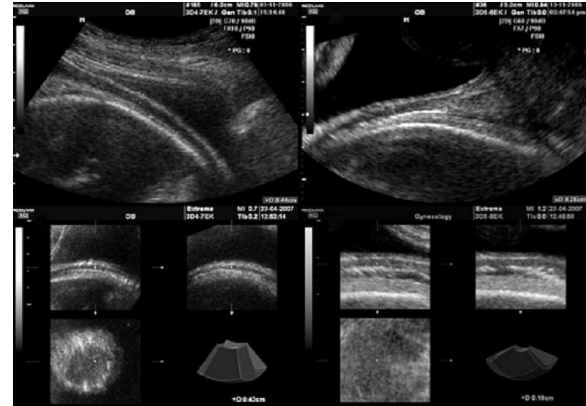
Images demonstrating measurement of the entire thickness of the lower uterine segment (LUS) by transabdominal two-dimensional (a) and three-dimensional (c) ultrasound, and of the muscular layer of the LUS by transvaginal two-dimensional (b) and three-dimensional (d) ultrasound (Martins et al., 2009).
